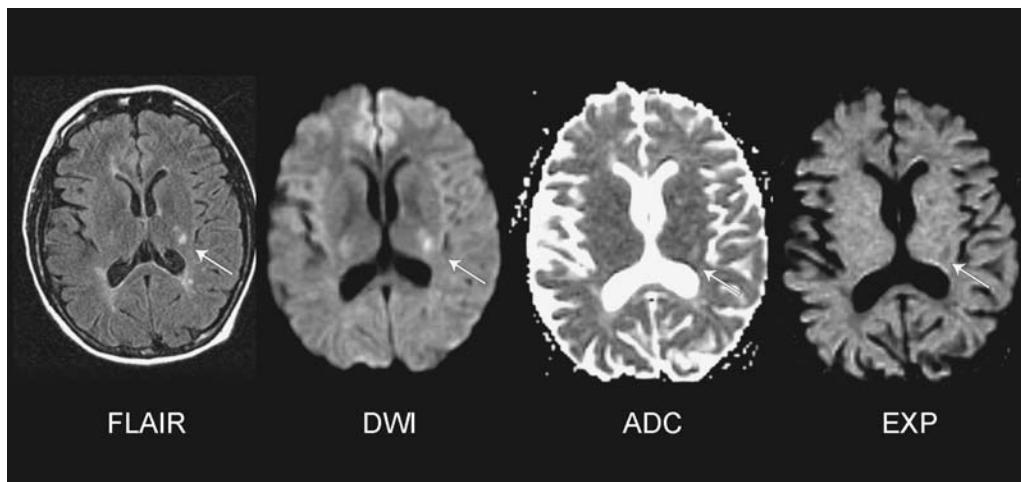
T2 shine through. Sixty-five-year-old female with mental status changes. DWI hyperintense lesion in the posterior limb of the left internal capsule is hyperintense on FLAIR images and ADC maps and hypointense on exponential images (arrow). These findings are consistent with elevated diffusion secondary to microangiopathic change rather than acute infarction suggested by the DWI images alone. Abbreviations: DWI, diffusion-weighted images; ADC, apparent diffusion coefficient; FLAIR, fluid-attenuated inversion recovery.
